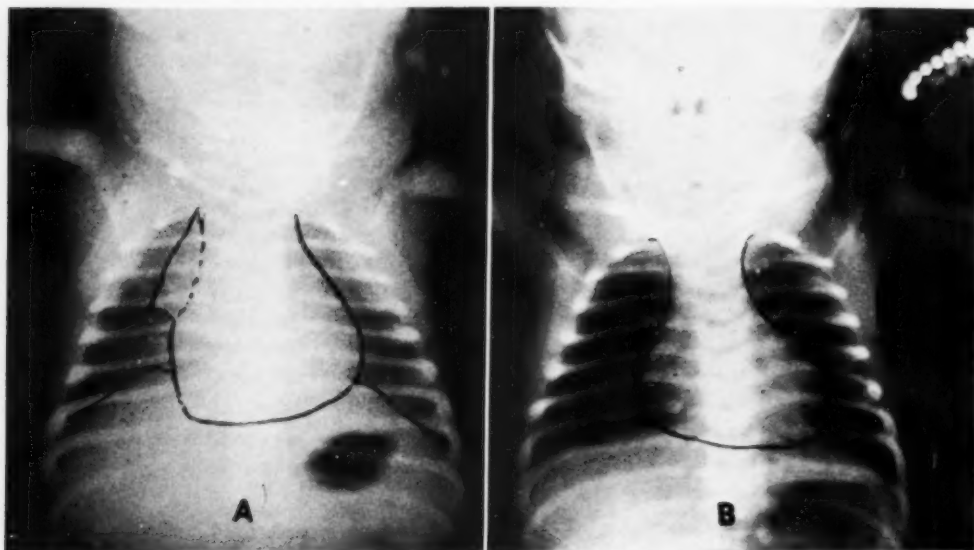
Retouched roentgenograms showing the large thymus shadow in Baby Girl D. No. 1 (A) and the absence of a thymus shadow in Baby Girl D. No. 2 (B).
